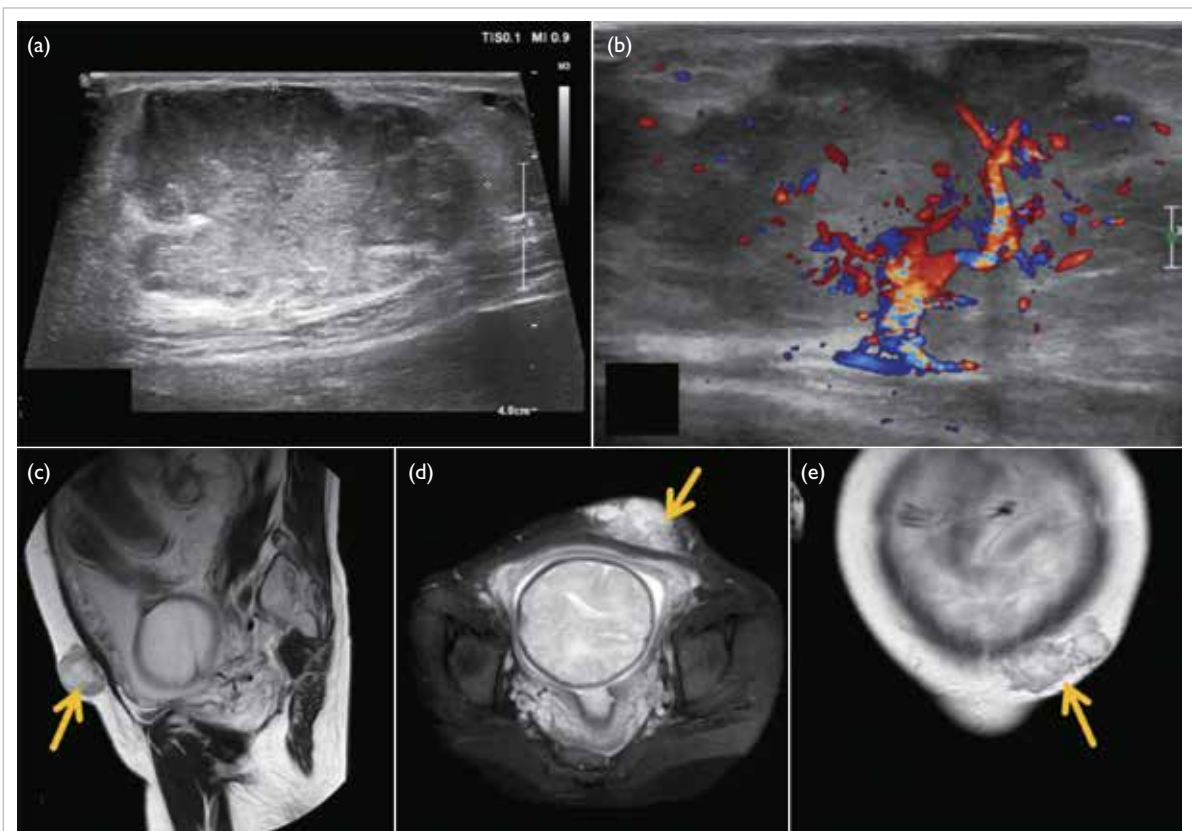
Ultrasound of the abdominal wall mass (a) showing abundant internal blood flow signals (b). (c) Sagittal T2-weighted imaging, (d) axial T2-weighted fat-saturated imaging, and (e) coronal T2-weighted imaging of fetal and abdominal wall mass. The yellow arrows indicate lobulated, coalesced lesions in the adipose layer of the left abdominal wall. The lesion appears heterogeneously hyperintense on T2-weighted imaging
